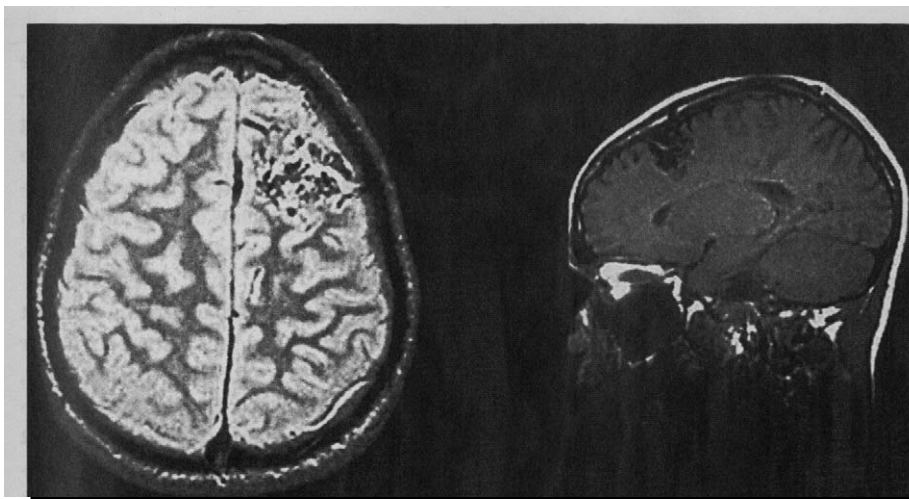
Preoperative magnetic resonance image of brain revealing left frontal arteriovenous malformation.
